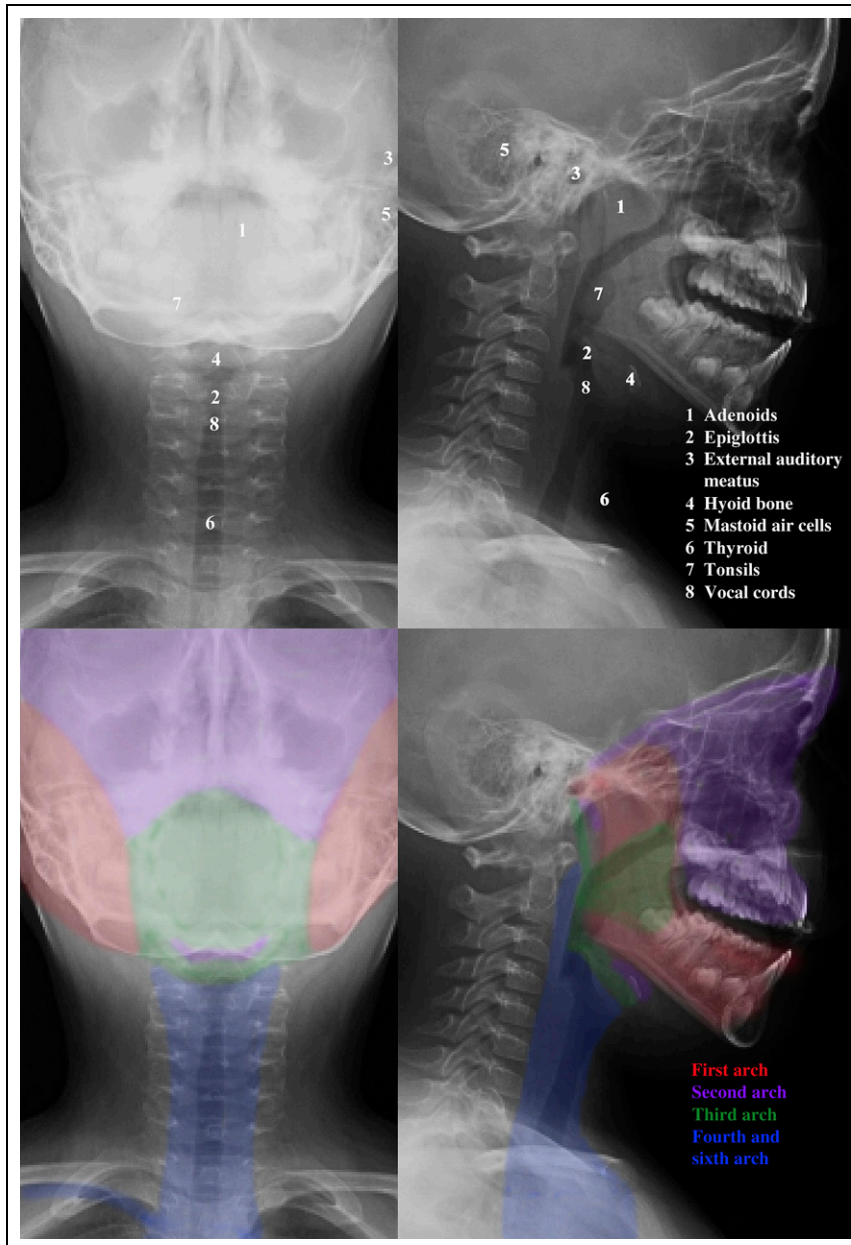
Key anatomic reference points and general areas of structures of the branchial arches demonstrated over radiographic image for anatomic orientation.
